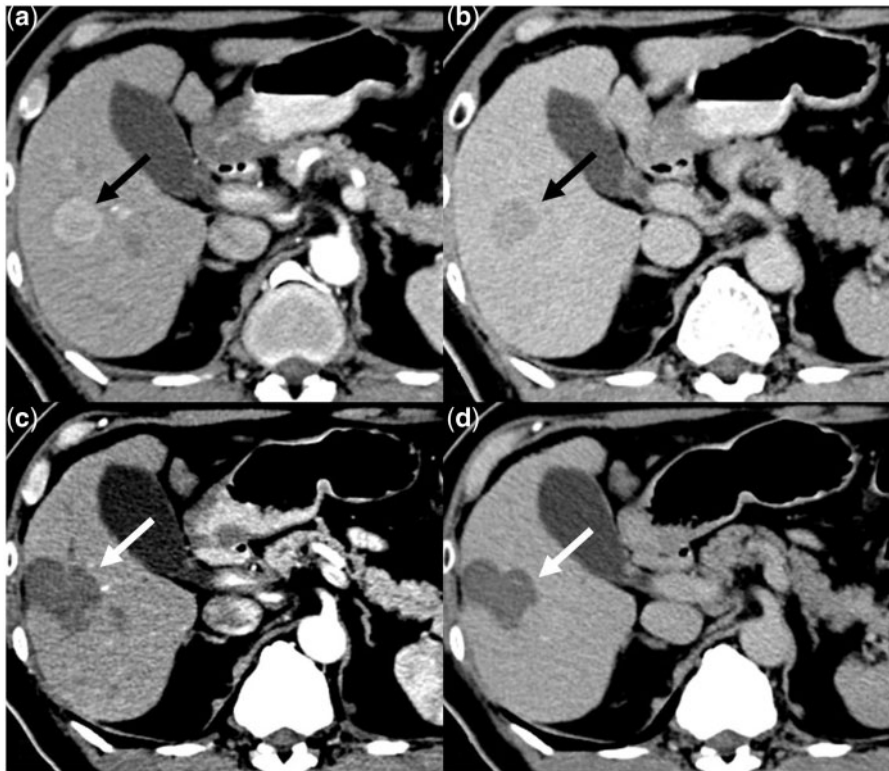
CT appearances before and after RFA of HCC. Top row: arterial (a) and portal venous phase (b) CT images showing an HCC (black arrow) before RFA. Bottom row: CT after 6 weeks of ablation; the HCC is replaced by a zone of hypodensity that is larger than the tumor and shows no enhancement (white arrow) in both the arterial (c) and portal venous phase (d).
